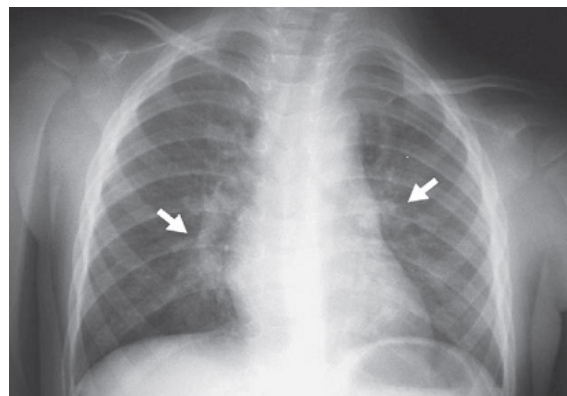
Chest x-ray – bilateral peribronchial and perivascular interstitial infiltrates
